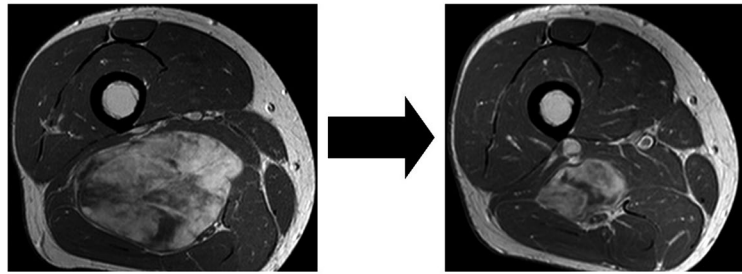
Axial Views of Contrast-Enhanced Computed Tomography Scans of a High-Grade Myxoid Liposarcoma of the Thigh Abutting the Sciatic Nerve. Studies were obtained (*Left*) before and (*Right*) after concurrent preoperative chemotherapy (doxorubicin and ifosfamide) and radiation (total dose, 50 grays).
